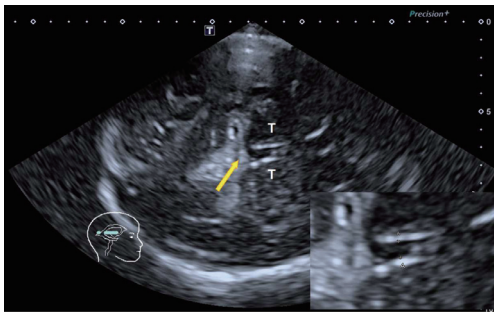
TCS image depicting the scanning planes at the thalamic level in a patient with PD. TCS image showing the V3 between the hyperechoic lines can be clearly visualized, and the yellow arrow points to the pineal gland, which is easily visible on TCS due to its high echogenicity. PD, Parkinson's disease; T, thalamus; TCS, transcranial sonography; V3, third ventricle.
